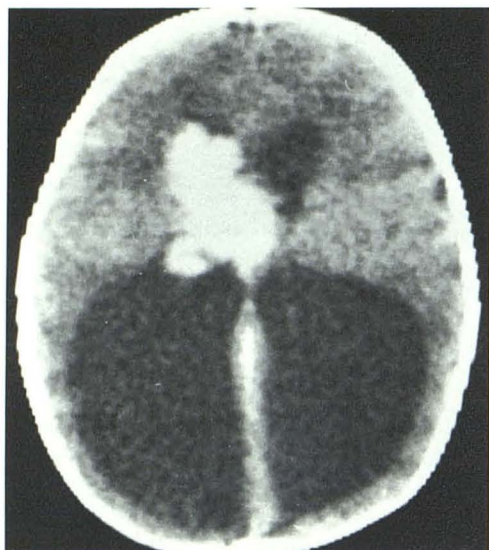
Preenhancement CT scan. Isodense lobulated intraventricular mass. After intravenous injection of contrast material, mass enhanced markedly and uniformly.
